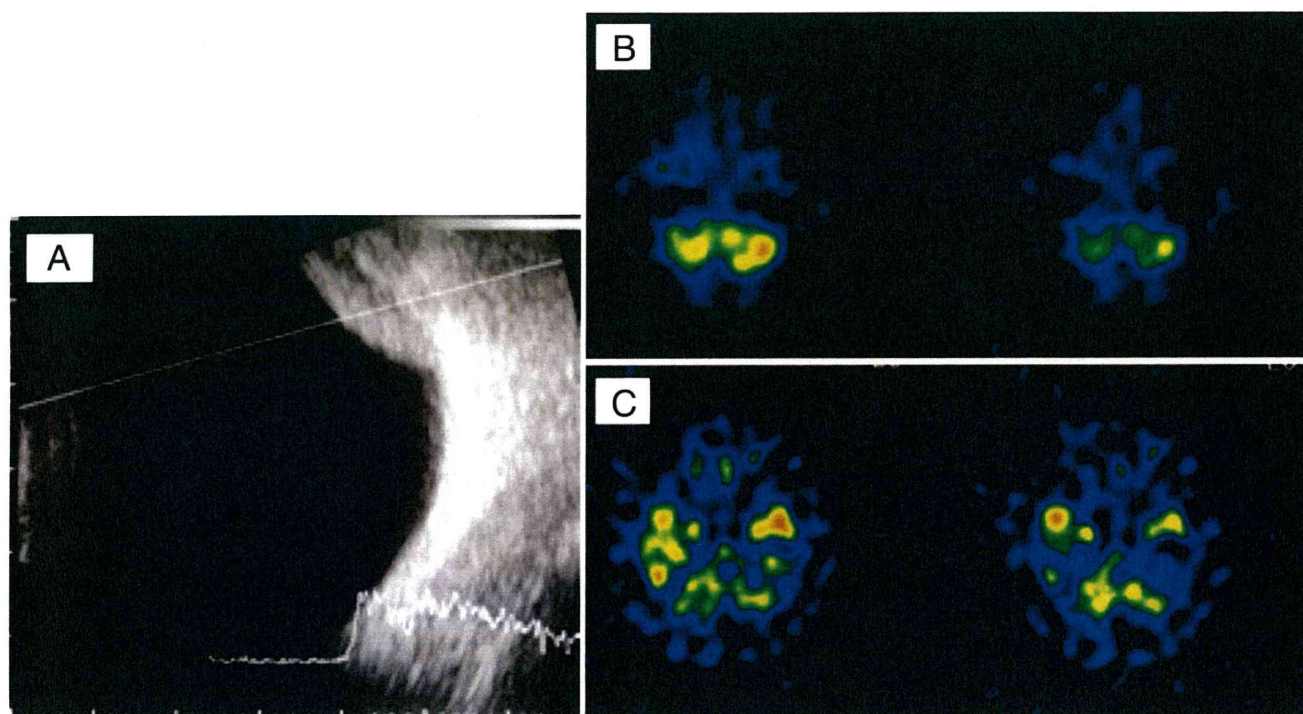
A Ultrasonography of a 65-year-old woman with left nevocellular nevus. It protruded to a height of 5 mm above the choroid. B, C I-123 IMP SPECT early and delayed images. Both images show low attenuation, so it is very difficult to establish the ROI without a 3D-ROI template. The retention index was 0.97, and the T/N ratio of the delayed phase was 1.03. This result reflects the natural course of 8 years of stability.
